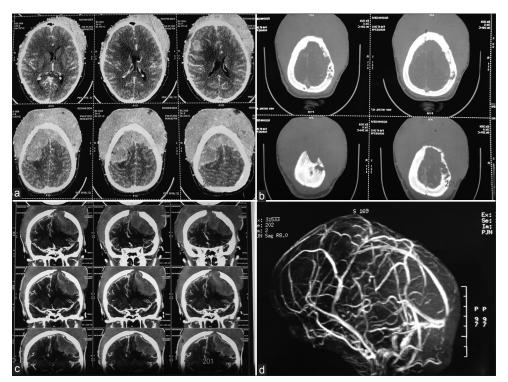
Computed tomography angiography brain (a-c) Large lobulated extra-axial mass lesion along bilateral frontal lobes with erosion and destruction of overlying calvarium and large extra-calvarial soft-tissue component. MR venography; (d) No flow in anterior part of superior sagittal sinus
